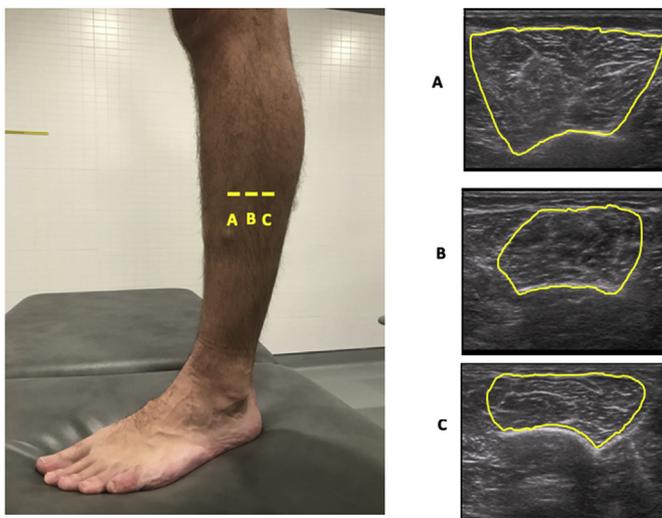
Ultrasound imaging CSA for the TA, EDL and PER muscles in transversal view.
